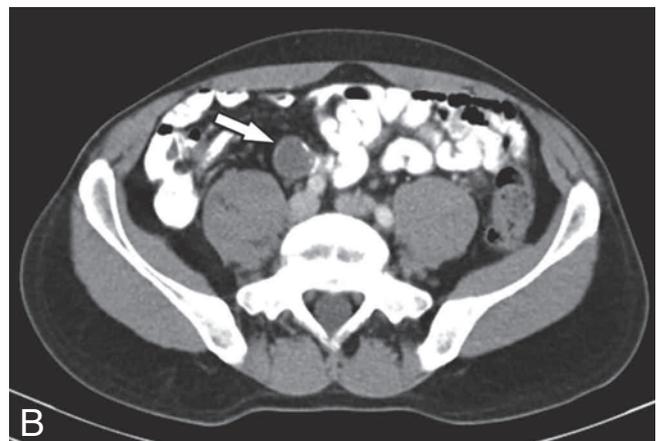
Sagittal (A) and axial (B) CT scan shows a cystic, oval-shaped mass in the right lower quadrant with punctate calcification in the wall of the lesion.
